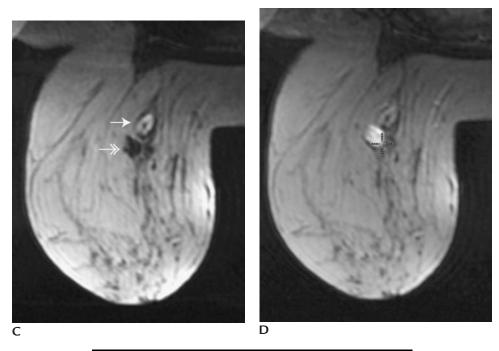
Invasive ductal carcinoma and adjacent postbiopsy hematoma. (A) Sagittal T2-weighted image. Irregular mass with bright (heterogeneous) signal. (B) Sagittal T1-weighted image. Mass demonstrates bright signal.
